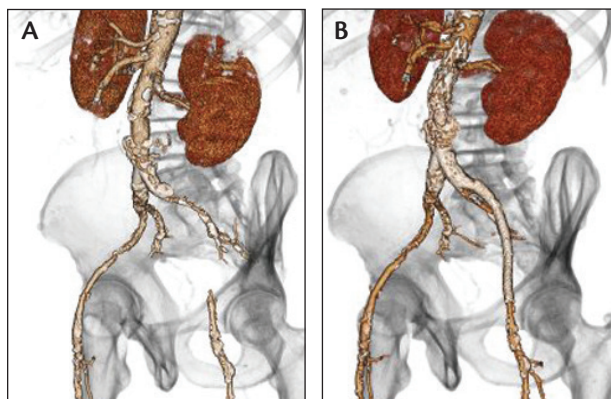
Pre- (A) and postoperative (B) CT angiograms of an AAA associated with extensive calcification and left external iliac artery occlusion treated with INCRAFT® Stent Graft System implantation and self-expanding stenting of the occluded vessel.
